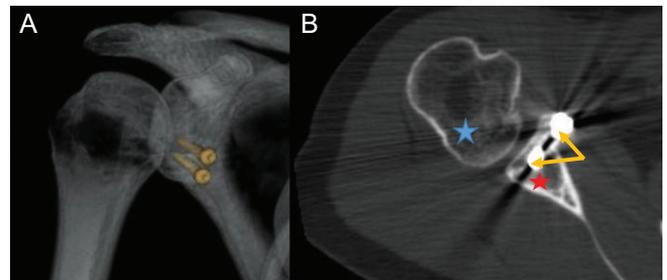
(A) Radiograph with visualization of Latarjet compression screws fixing the coracoid graft to the anterior glenoid. (B) CT scan, coronal view, showing a postoperative image after a Latarjet procedure with the humeral head (blue star), the compression screws (yellow arrows), and the glenoid (red star).
